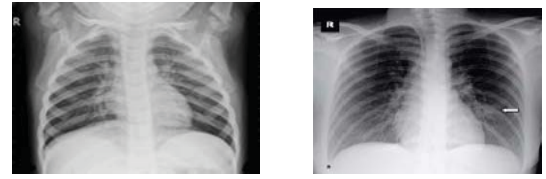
Sample chest x-ray images of covid and normal patient
